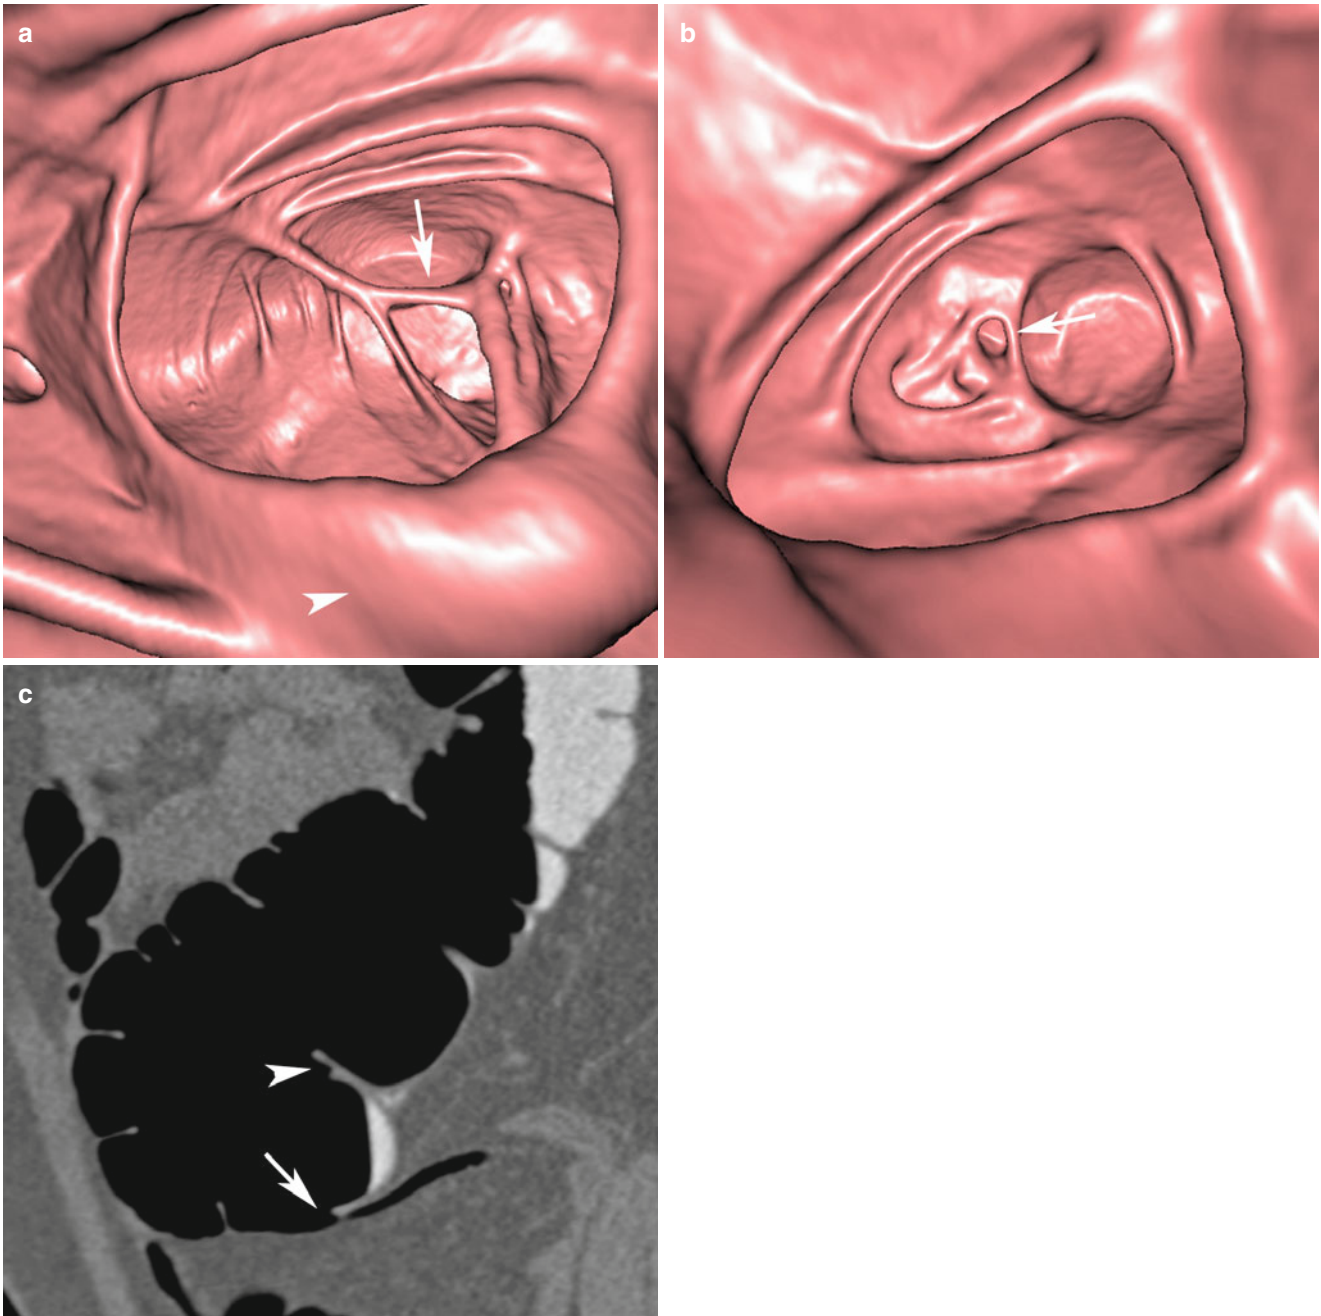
(a) Retrograde endoluminal 3D CT image of the cecum, showing the three colonic taeniae converging and forming the triradiate fold (*arrow*). Note the papillary ileocecal valve (*arrowhead*). (b) Retrograde endoluminal 3D CT image of the cecum in another patient, showing the appendiceal orifice at the area of the triradiate fold (*arrow*), appearing
